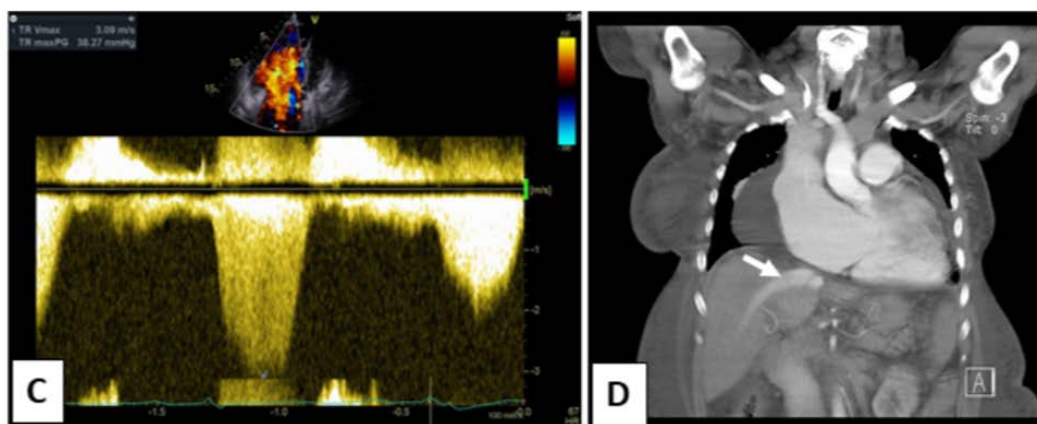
C. TTE 2D showed TR Severe and Main Pulmonary Artery Dilatation; Abdominal computed tomography findings revealed engorgement of the hepatic vein (black arrow, D
